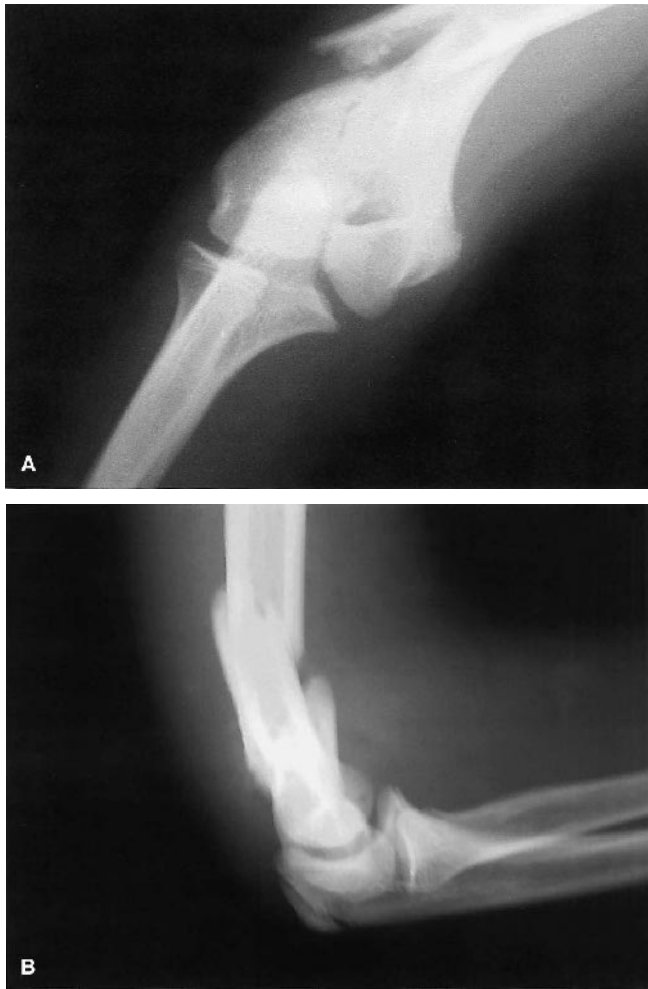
Anteroposterior (A) and lateral (B) radiographs of the right elbow in the 14-year-old patient, on admission.
